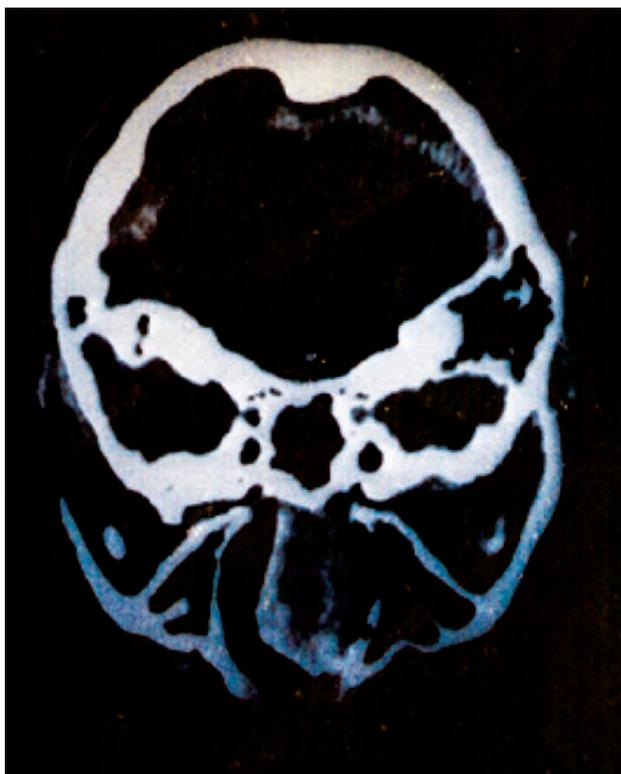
Cranio-facial CT examination, axial slice - neurofibroma of the right nasal fossa
